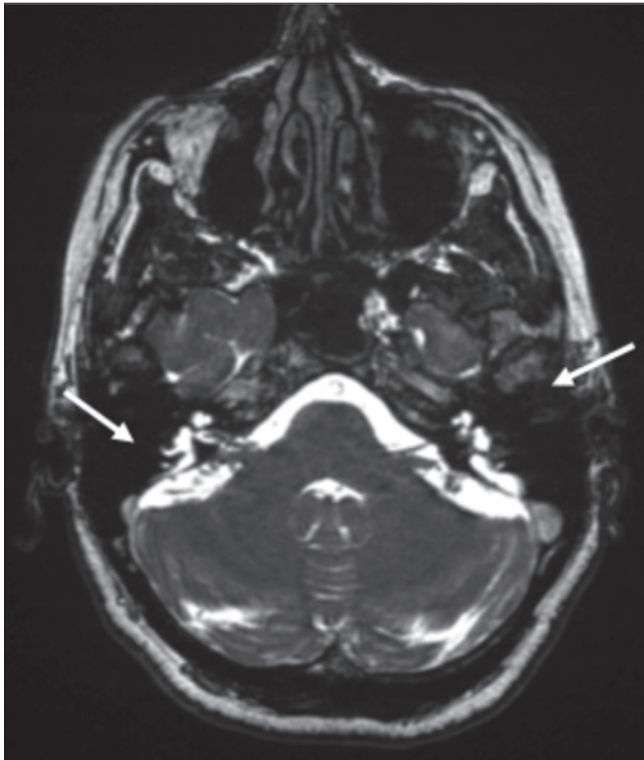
Axial section MRI (FIESTA). Enlarged vestibular aqueduct (arrows).
